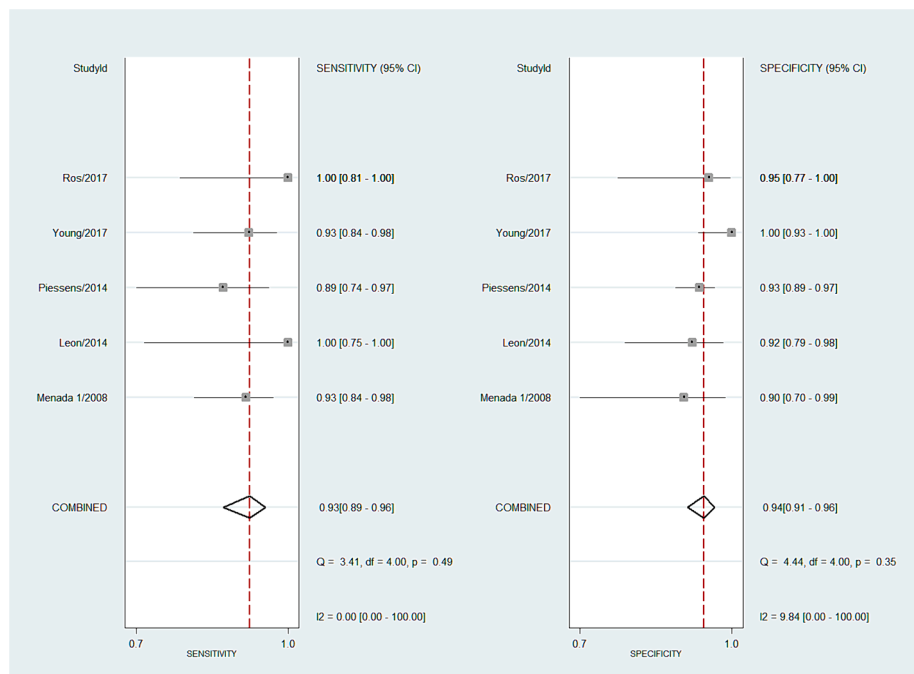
Forest plot for sensitivity and specificity for all studies concerning the diagnostic performance of transvaginal ultrasound with bowel preparation.
